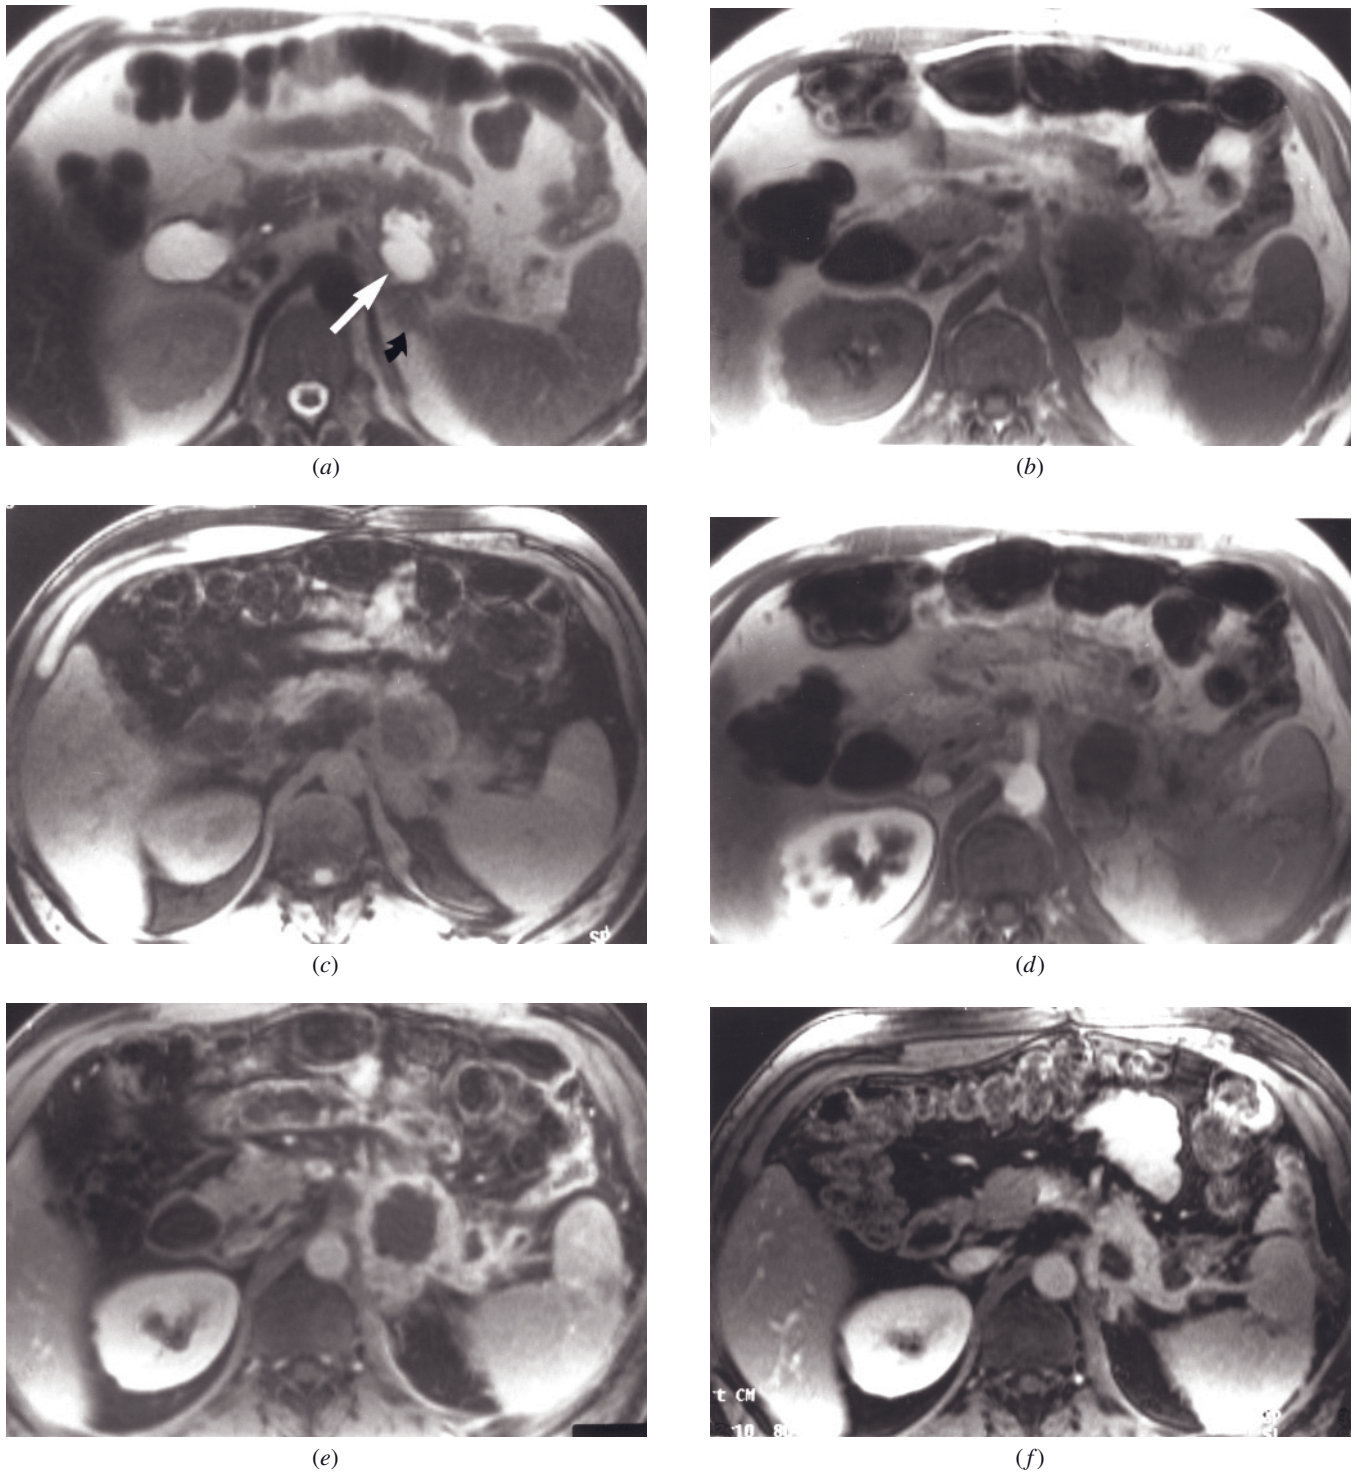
Pancreatic metastasis from transitional cell cancer. T2-weighted ETSE (a), T1-weighted SGE (b), T1-weighted fat-suppressed SGE (c), immediate postgadolinium T1-weighted SGE (d), and 90-s postgadolinium fat-suppressed SGE (e) images in a patient with recurrent transitional cell cancer, originally from the left kidney. There is a cystic mass (arrow, a) that involves the pancreatic tail and the left adrenal gland (curved arrow, a). A thick enhancing rim is demonstrated on the interstitial-phase gadolinium-enhanced fat-suppressed image. Interstitial-phase gadolinium-enhanced fat-suppressed SGE image (f) obtained after a course of chemotherapy demonstrates substantial decrease in size of the cystic mass.
